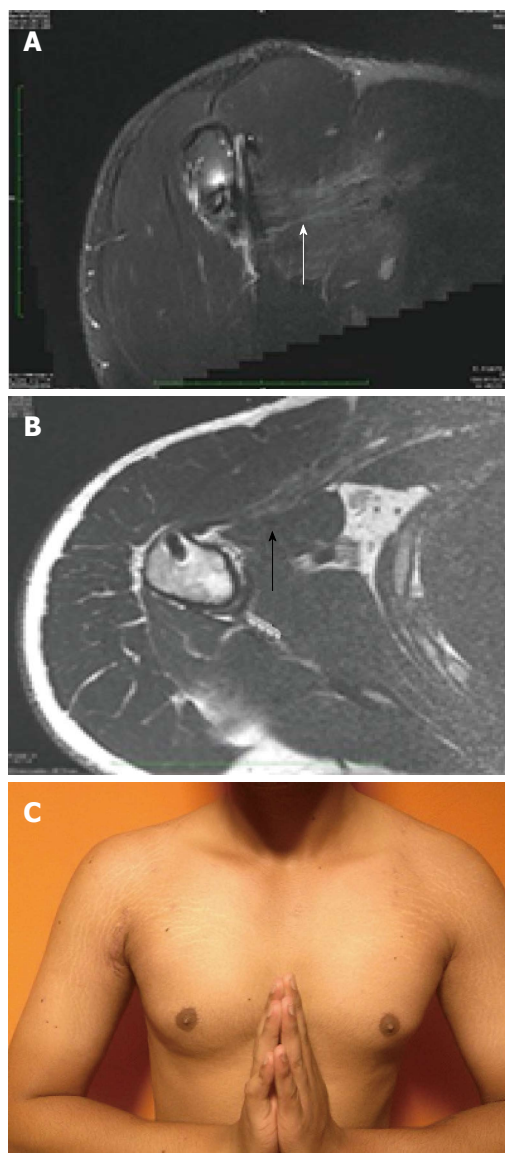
Magnetic resonance imaging at 6 mo follow up showing excellent continuity (arrow) and the bulk of pectoralis major muscle after repair (A, B); restoration of the anterior axillary fold after surgery (C).
